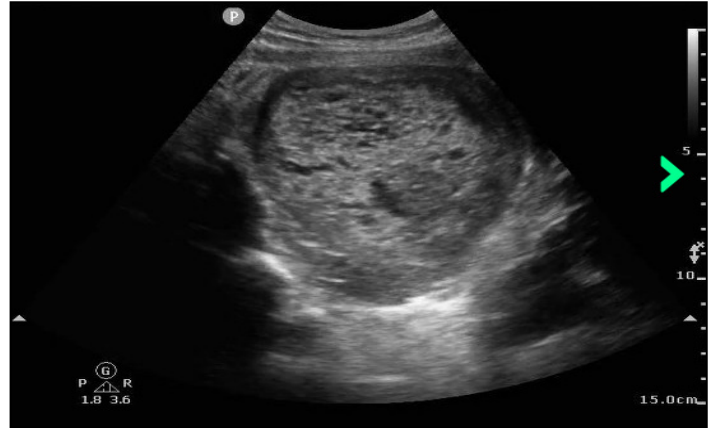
Representative transabdominal ultrasound image of a molar pregnancy
